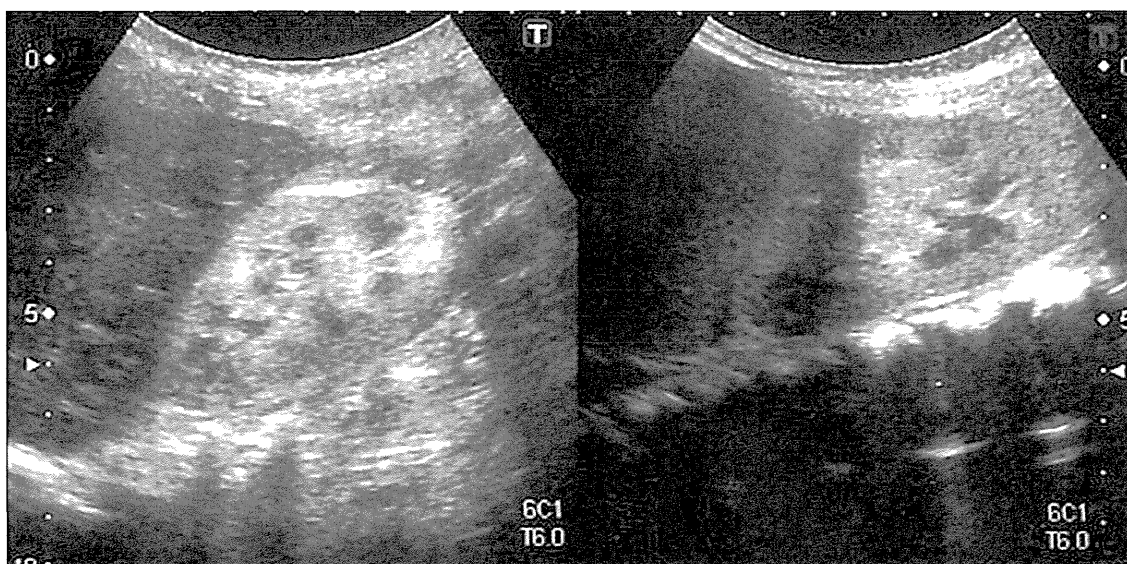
Increased echogenicity of renal ultrasound in a patient with HUS
